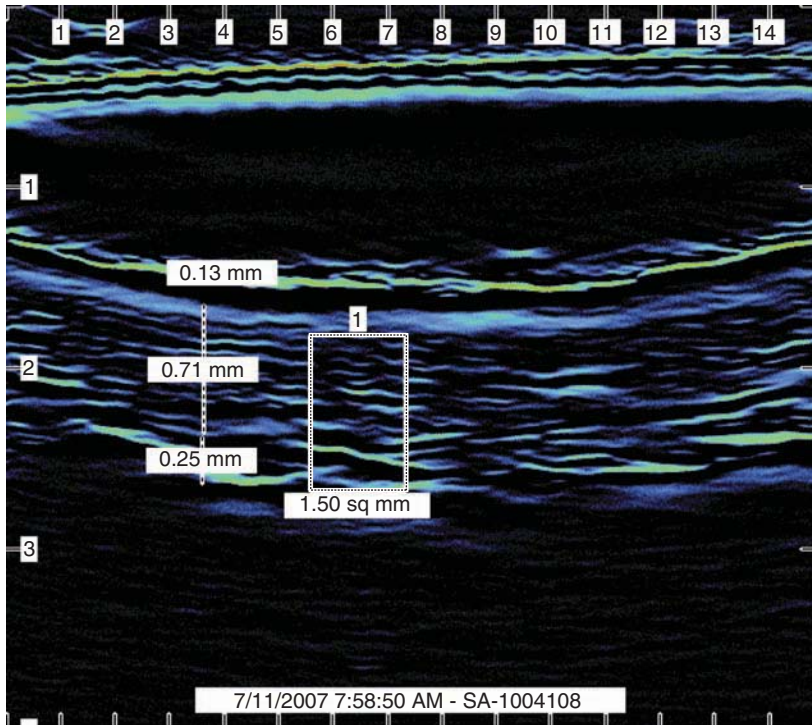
Ultrasound image of the skin of a lower leg scan before treatment. (Source: Essex Testing Clinic, Inc., Verona, NJ)
